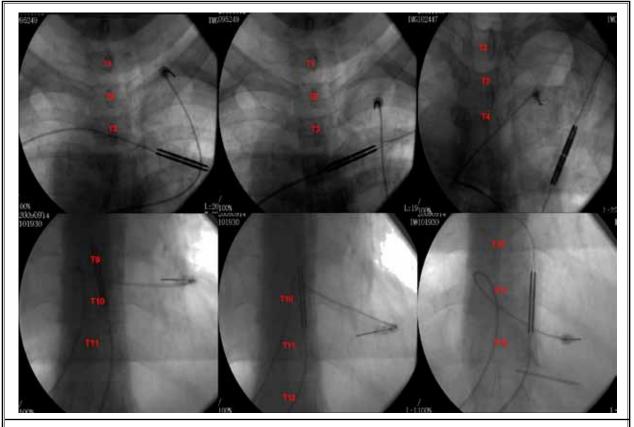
X-ray photo of PRF treatment. For PHN of the T3 segment, the T2, T3, and T4 thoracic intercostal nerves were selected for PRF treatment. For PHN of the T10 segment, the T9,T10 and T11 thoracic intercostal nerves were selected for PRF treatment.
